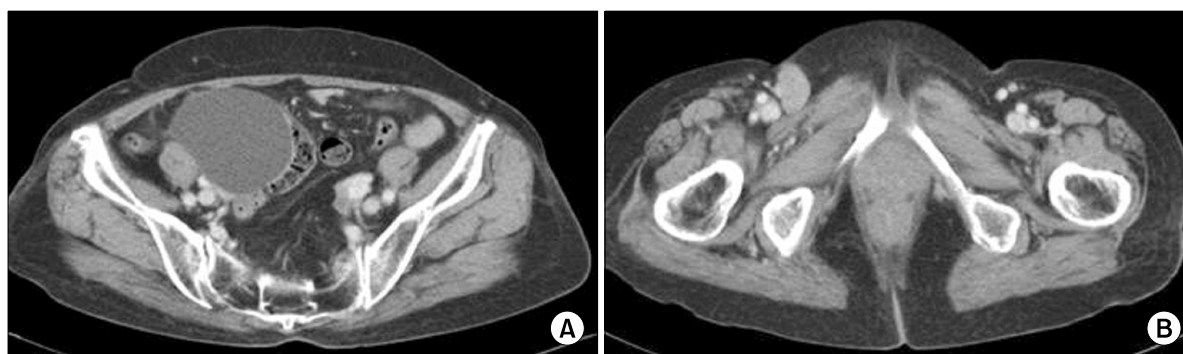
Pelvic CT (postenhancement). (A) It showed about 7.0×6.7 cm sized, unilocular, thin walled, non-enhancing hypodense mass at right adnexa, and (B) about 2.4×1.4 cm sized, round to ovoid, homogeneously enhancing nodule at right superficial inguinal region.
